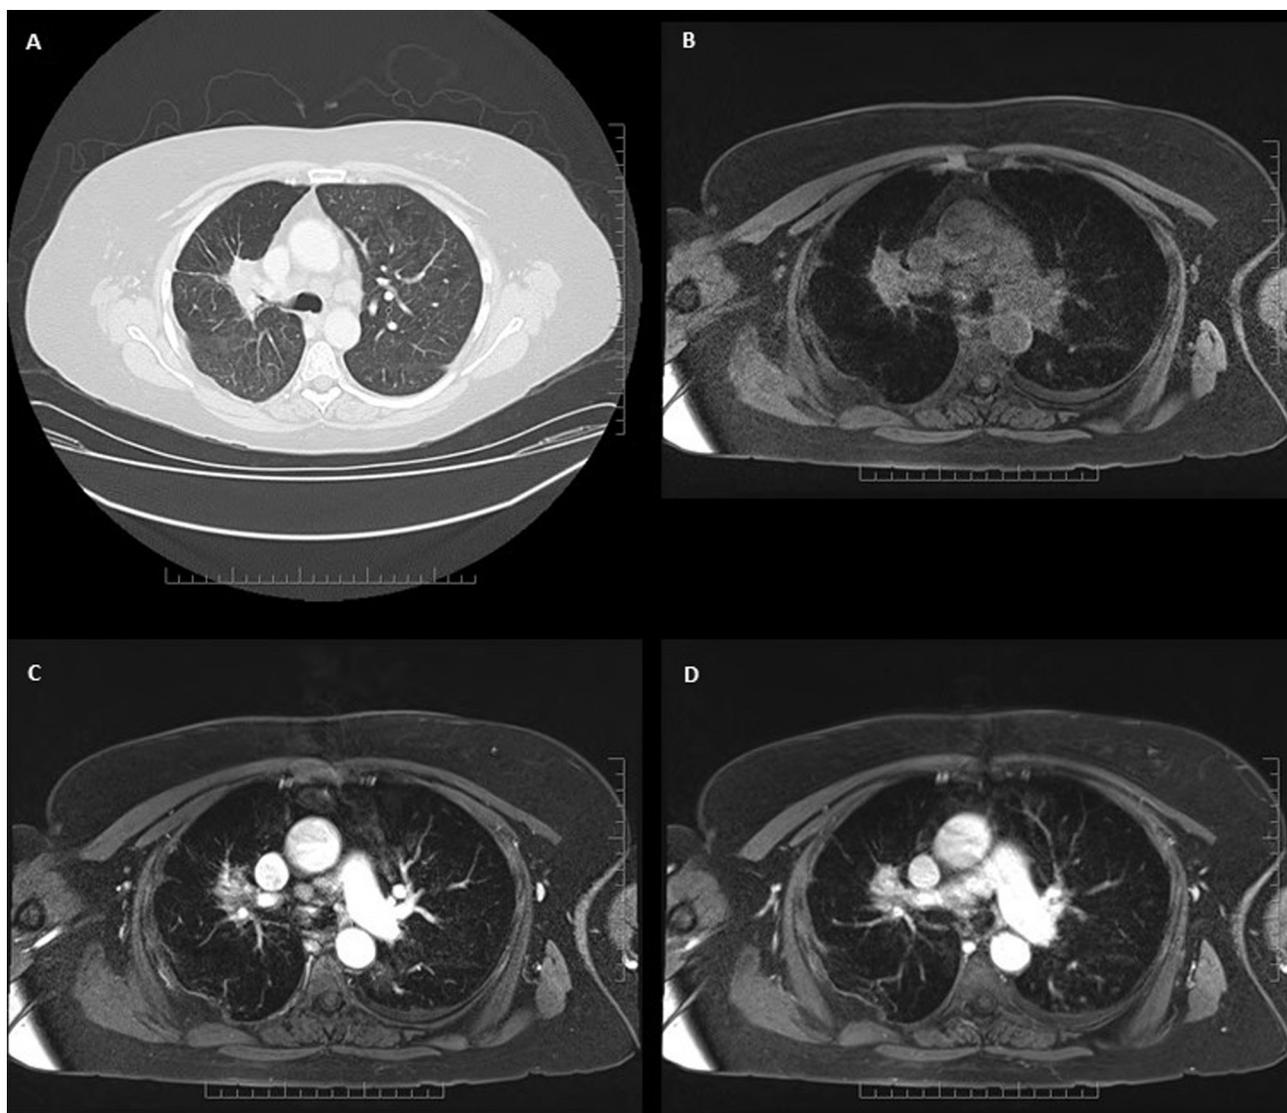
Example of a patient with a follow-up computed tomography scan scored as equivocal for recurrence (A). (B) 3.0T T1 sequence before contrast administration. (C) and (D) Dynamic contrast-enhanced assessment at 20 s and 1 min after contrast administration. A magnetic resonance imaging assessment diagnosed these findings as benign, which was later confirmed on subsequent follow-up.
